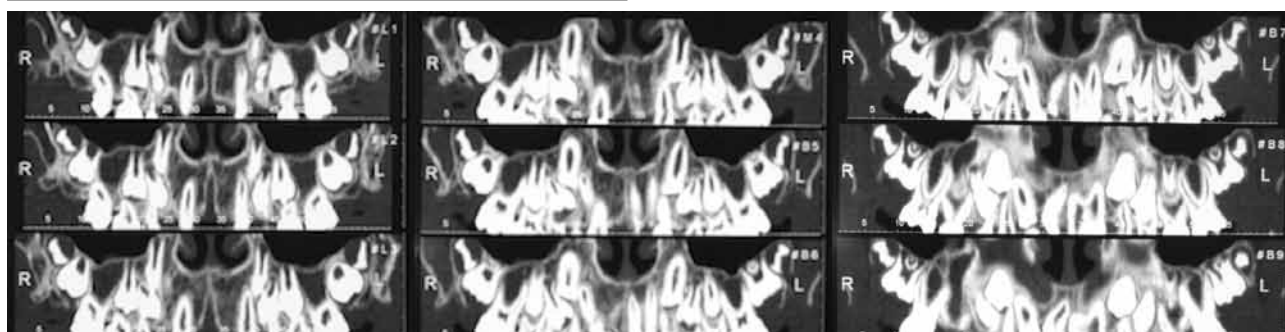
Preoperative panoramic radiograph and preoperative computed tomography images.
